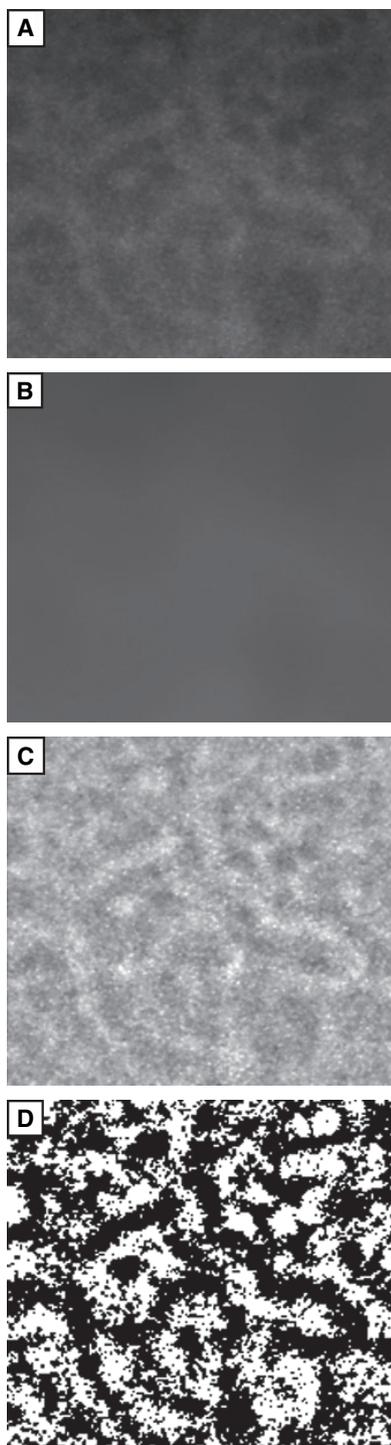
Steps used in image processing. (A) Original dental radiograph in anterior mandible. (B) Blurred image created using a Gaussian filter with a sigma of 10 pixels. (C) Image of original radiograph made uniform in overall lighting intensity by subtracting blurred image (B) from original (A). (D) Binary image, derived from Fig. 1 panel (C) using ImageJ software.
